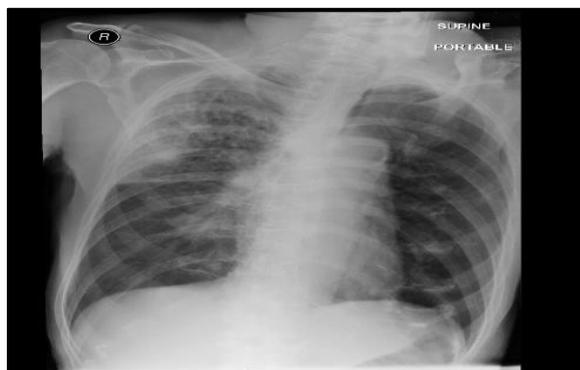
Chest x-ray -right upper lobe consolidation.
